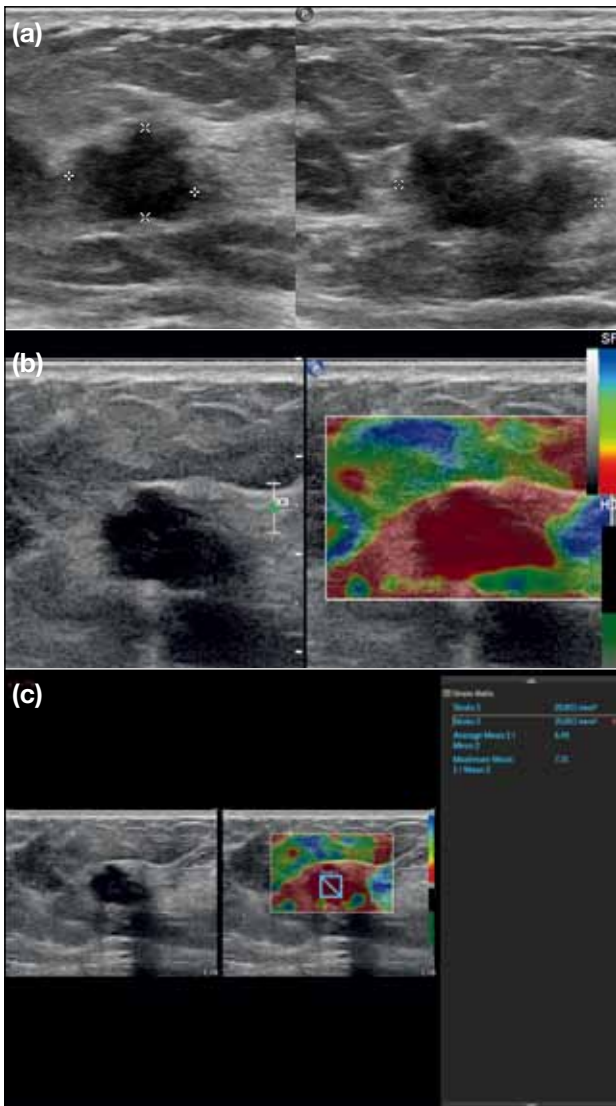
Triple-negative invasive ductal carcinoma. (a) B-mode ultrasonography. An irregular hypoechoic nodule with microlobulated margin, Breast Imaging Reporting and Data System (BI-RADS) category 4 based on conventional B-mode ultrasound findings alone. (b) Strain elastography. The entire lesion and the surrounding breast tissue were shaded in red, ie, stiff (elastography colour scheme from blue to red represents soft to hard). Elasticity score was 5. (c) Gland/lesion strain ratio was 6.44, higher than the optimal cut-off of 2.62 in our study. Together with elastography parameters, BI-RADS was upgraded from category 4 to modified BI-RADS category 5 based on the equation of $4 + 1 + 1 = 6$ (>5 was taken as 5), ie, modified BI-RADS category 5.
